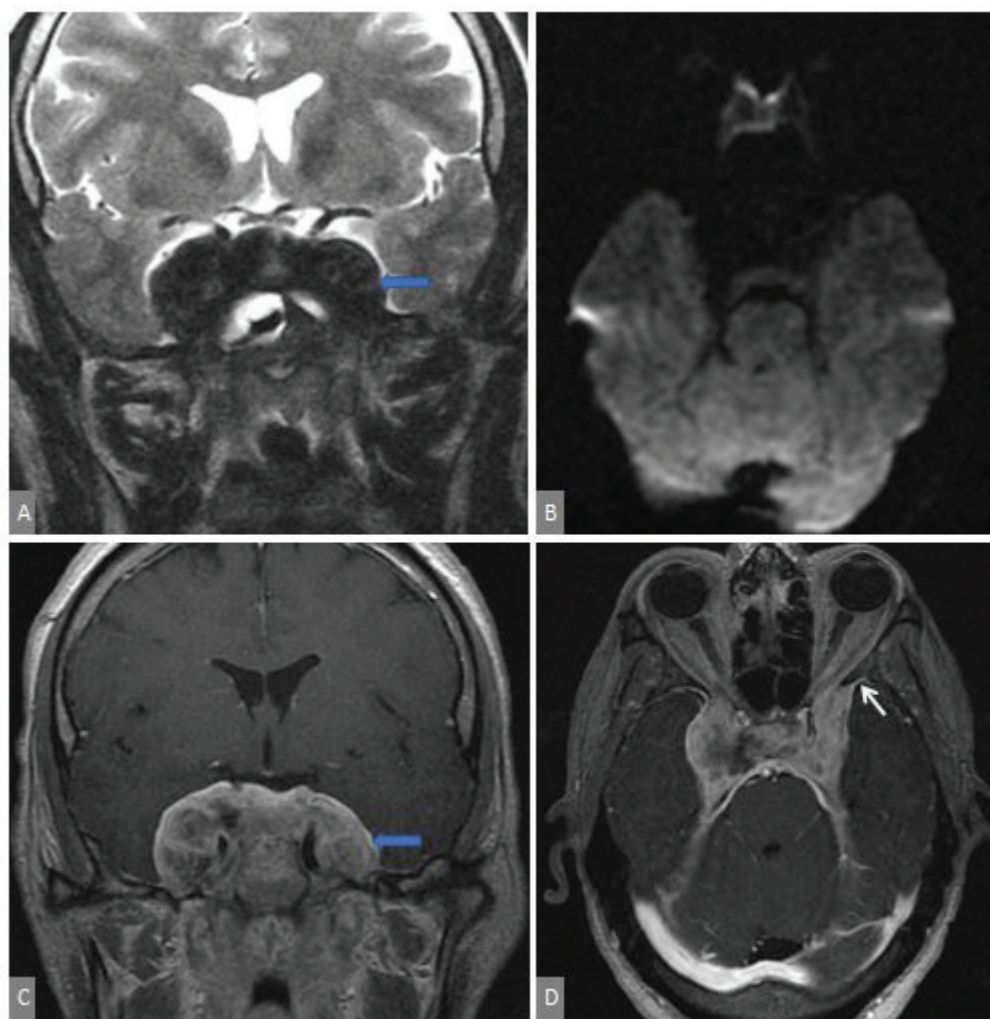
A 58-year-old woman presenting with a 3-week history of bilateral painful ophthalmoplegia. Coronal T2-weighted MRI (1.5 T) (a) demonstrates a well-defined extra-axial lesion with bilateral cavernous sinus involvement, appearing hypointense relative to brain parenchyma, consistent with its fibrous composition. Axial diffusion-weighted imaging (b) shows no diffusion restriction. Coronal (c) and axial (d) post-gadolinium T1-weighted images demonstrate heterogeneous enhancement with a dural tail sign (white arrow), consistent with cavernous sinus meningioma. All images are fully anonymized and reproduced with written patient consent.
